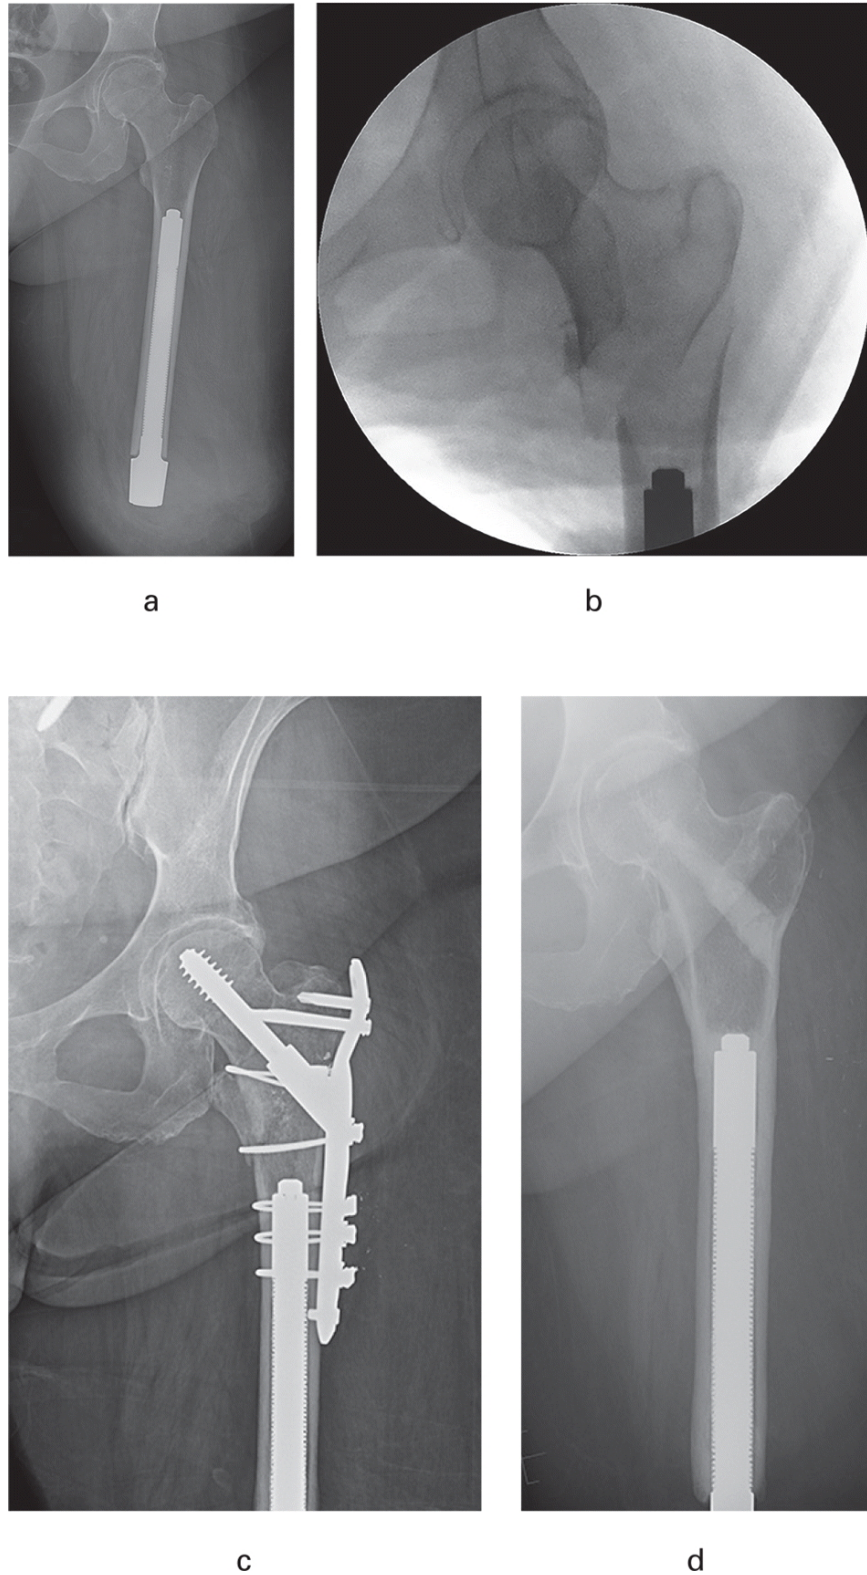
Periprosthetic fracture fixation. Anteroposterior radiographs (A, C, and D) and image intensification (B) of a 64-year-old woman who had a left transfemoral amputation for chronic infection after total knee arthroplasty. (A) immediate post osseointegration appearance (15 years and two months after amputation). (B) she sustained an intertrochanteric fracture eight months later. (C) she was treated with a hybrid dynamic hip screw with features of a reconstruction plate. (D) there was persistent discomfort, and the hardware was removed one year later. She has not needed further care in the subsequent six years.
